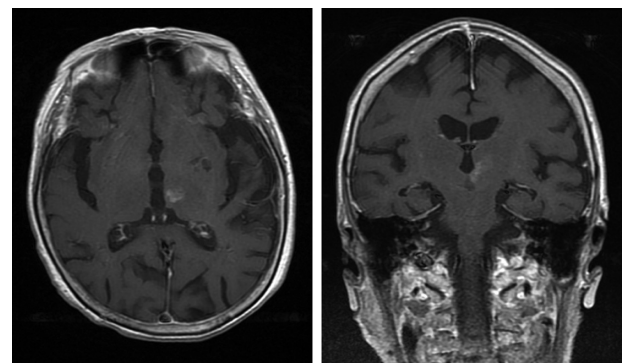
MR images (T1-weighted image with contrast medium) revealed small infarction at the posteromedial of left thalamus.
